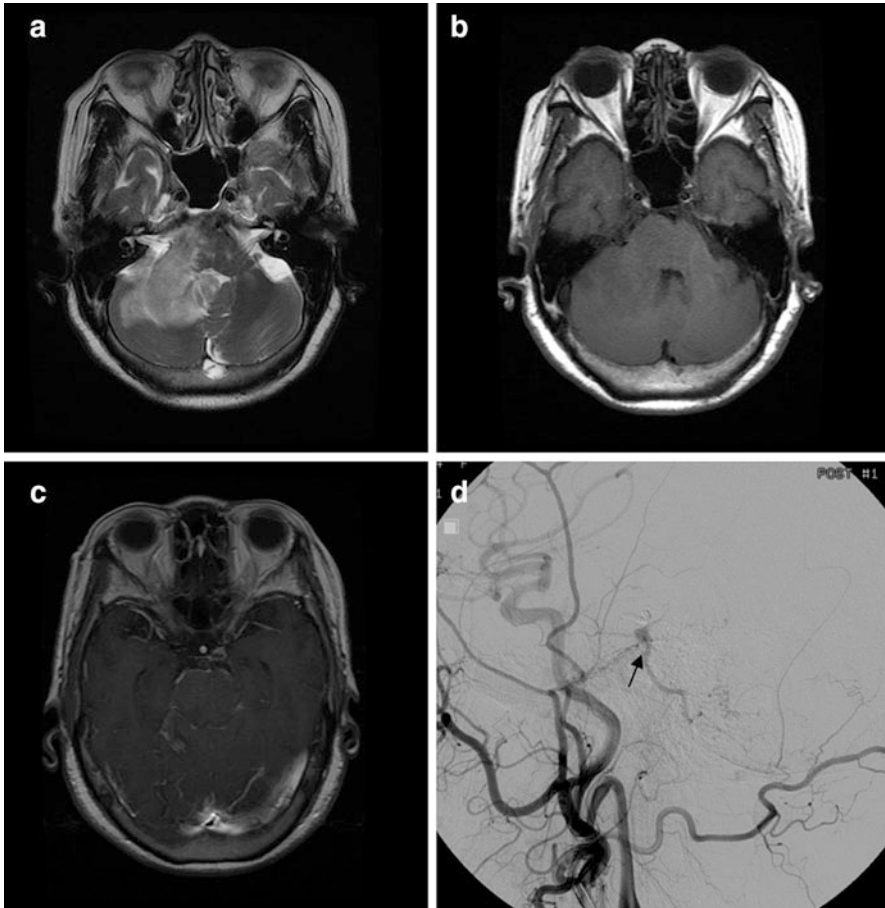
Cerebellar venous infarction. MR images show high signal intensity on T2-weighted images (a) and low signal intensity on T1-weighted images (b) at right cerebellar hemisphere, cerebellar peduncle, and pons. Subtle peripheral enhancement on gadolinium-enhanced T1-weighted images (c) at lower pons and cerebellar peduncle is observed. Conventional angiography (d) confirms dural arteriovenous fistula draining into the right superior petrosal vein (*arrow*)
